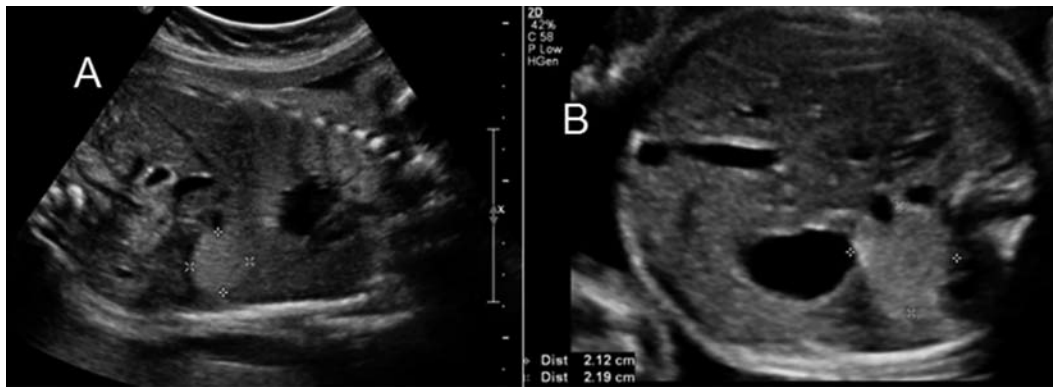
Antenatal ultrasound image showed a left sub-diaphragmatic suprarenal lesion in a 30-week fetus (longitudinal and cross section view).
